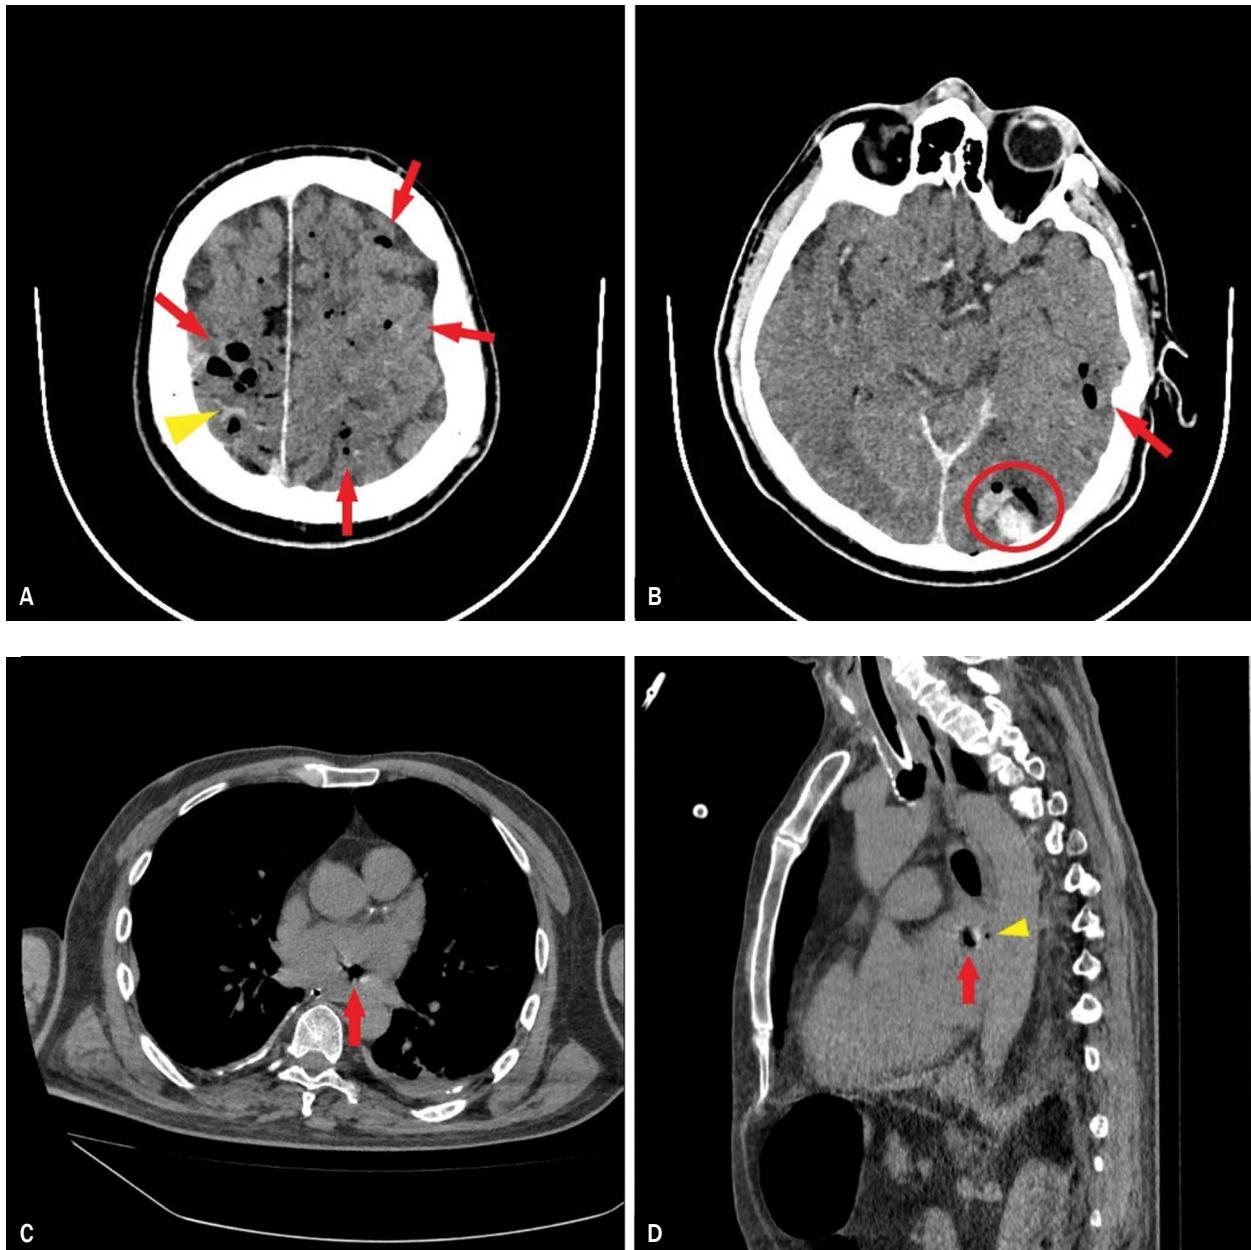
A follow-up non-contrast brain computed tomography (CT) performed right after the coronary angiography: multiple cerebral and cerebellar air emboli (red arrows), hyperdense material in sulci of the right parietal lobe (arrowhead), focal hyperdense areas containing small air densities (circles); C, D. Non-contrast chest CT showed gas densities in the left atrium (red arrow) and pericardial cavity (yellow arrowhead) suggesting atrioesophageal fistula atrioesophageal fistula (AEF) presence
